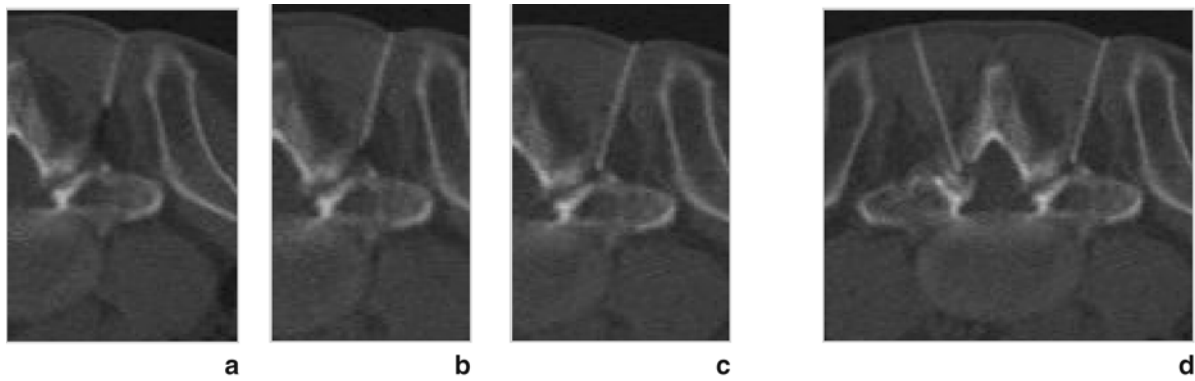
(a–d). Needle penetration to the lysis points under CT guidance (a–c) and correct needle placement (d) (arrowheads)
